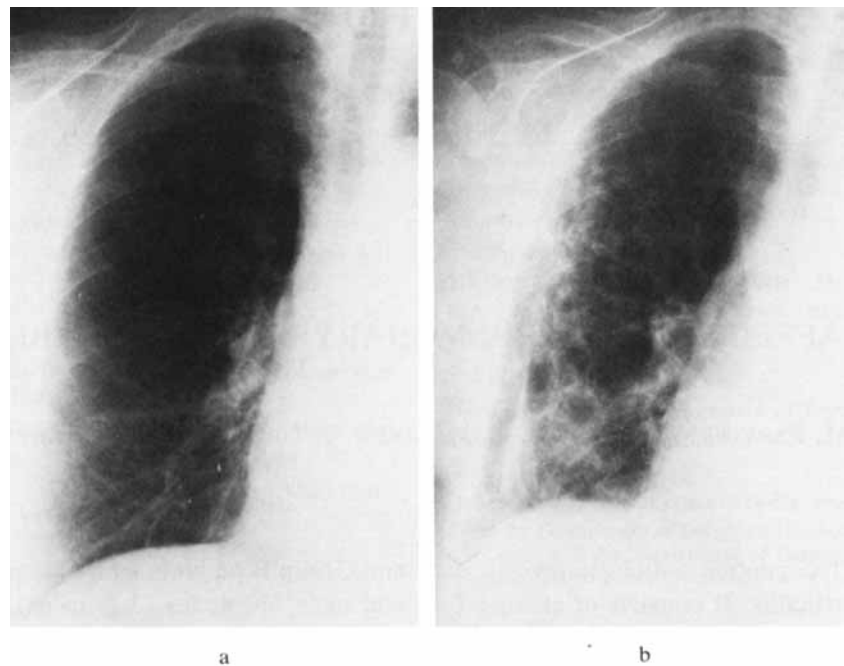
Woman aged 76 years. a) Conventional chest roentgenogram before treatment. b) Thickening of the lateral pleura and parenchymal lesions 42 days after beginning of bleomycin therapy (total dose 240 mg).
